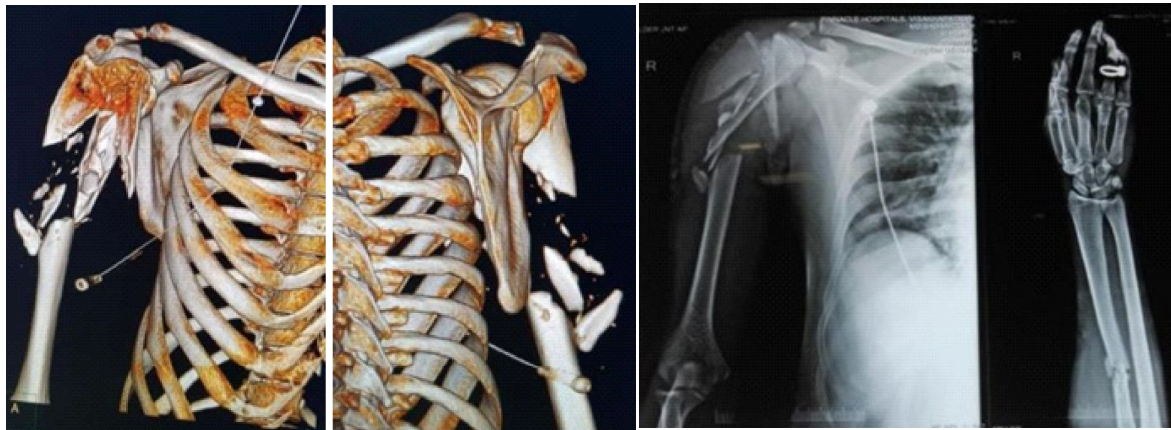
(A) X-Ray radiograph of the right shoulder and right forearm
